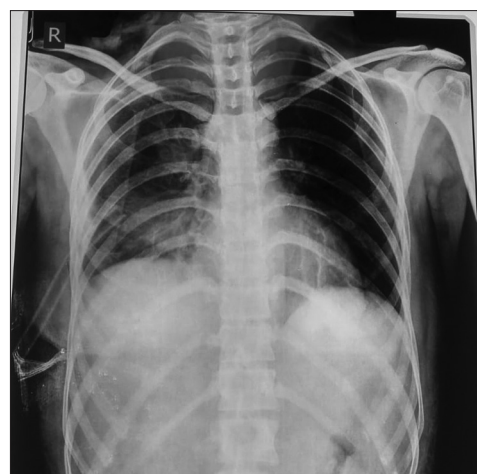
X-ray after chest tube insertion depicting resolution of the effusion
